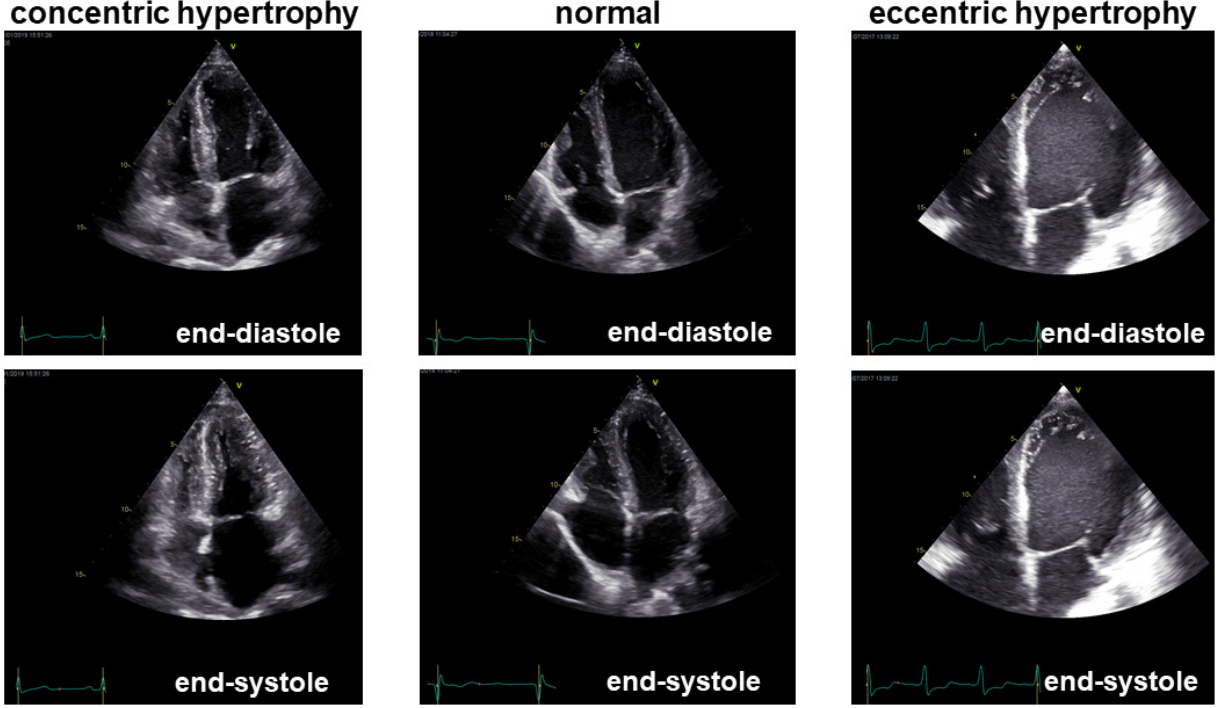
Echocardiography (4 chamber view) shows advanced structural changes at end-diastole and end-systole with concentric (left panels) or eccentric (right panels) hypertrophy. The left ventricle is shown in the upper right part of each image, with the apex on top and the left atrium at the bottom right. Compared to normal (central panels), concentric hypertrophy results in left ventricular wall thickening and cavity squeezing in systole. At the opposite, eccentric hypertrophy results in wall thinning and cavity dilatation. Courtesy of J.J. Bax and V. Delgado, Univ. of Leiden Medical Center.
